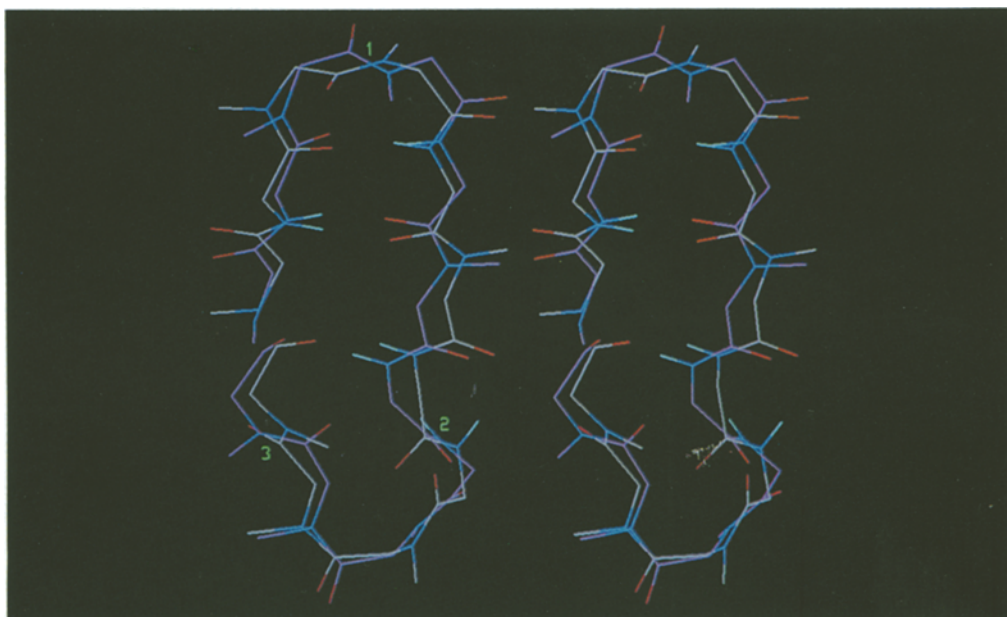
Superposition of the DISMAN-generated ring conformation 4B (see Table 2) with the X-ray structure of cyclosporin A backbone (RMSD = 1.25 Å). Structure 4B (red) shows the best fit from 90 generated conformations.
